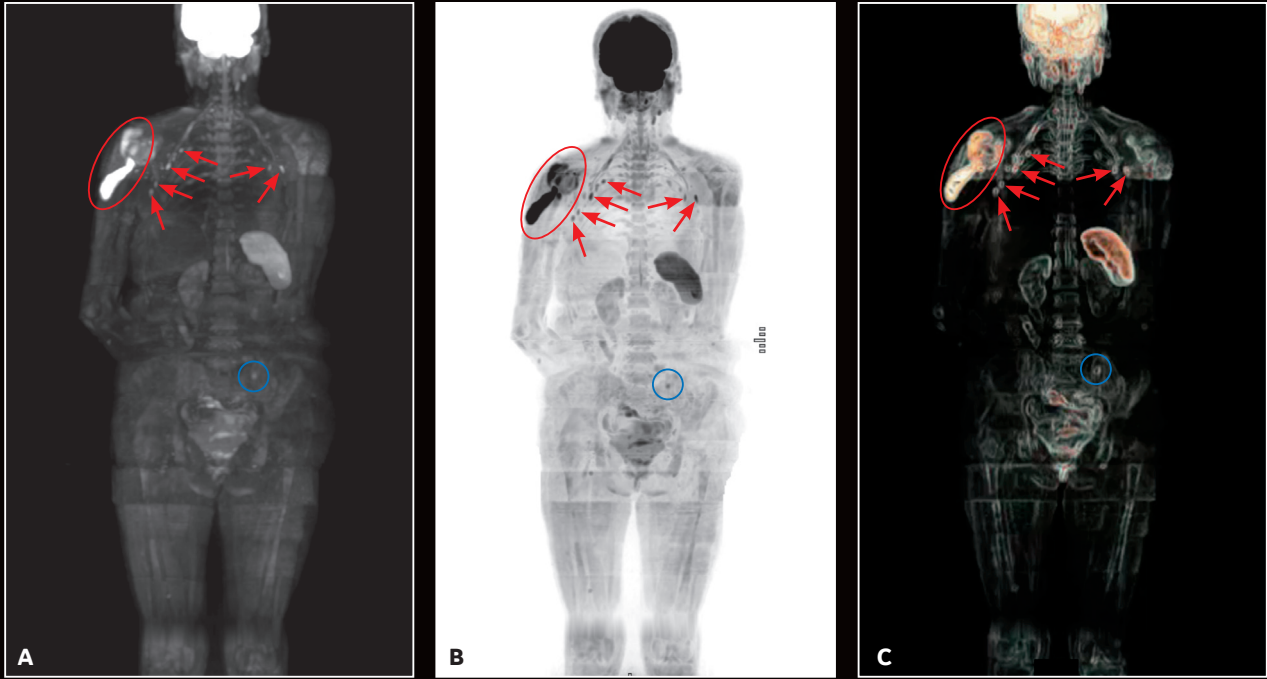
Whole-body MR imaging with approximately 120 cm coverage. Binded Axial diffusion STIR 3-in-1, b600, 4.4 x 4.4 x 3 mm, 20 stations, 36:20 min. (A-B) MIP projections; and (C) volume rendered image. Red circle depicts the effusion on the glenohumeral joint of the right shoulder. Red arrows show the bilateral swollen axillary lymph nodes. Blue circle denotes the lesion on the left iliac joint.
